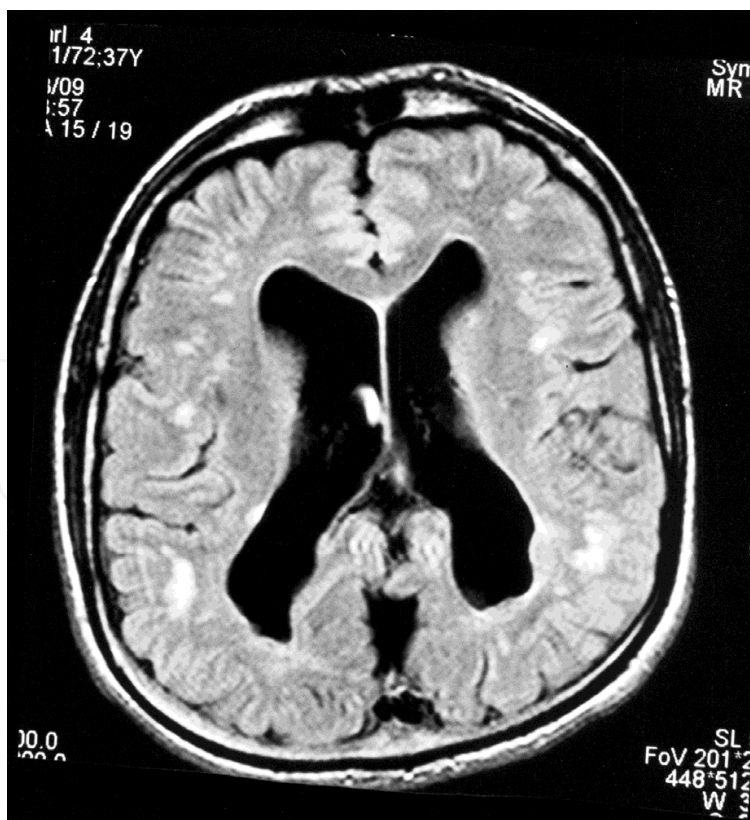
MRI of the brain: Axial T1-weighted image shows multiple bilateral subependymal heterotopia of grey matter.
